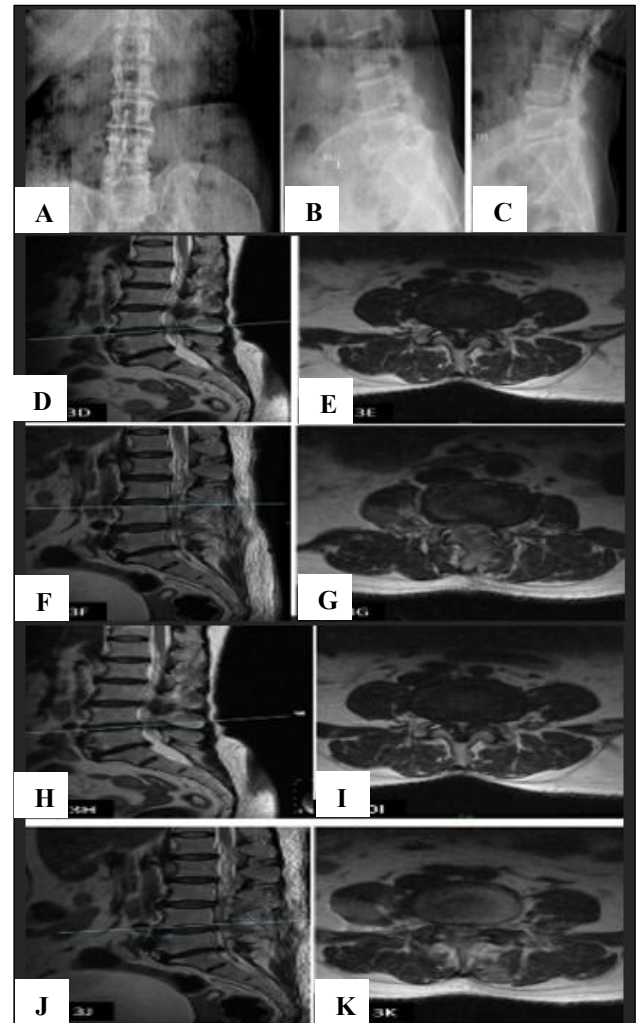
Case Example 3: 65-year-old male with lumbar canal stenosis at both L3-L4 and L4-L5, presenting with left lower limb radiculopathy. (A to C) Show AP, lateral in flexion, and lateral in extension radiographs, D and E) Depict preoperative sagittal and axial T2-weighted MRI images at the L3-L4 level, demonstrating severe neural compression, (F and G) Display preoperative sagittal and axial T2-weighted MRI images at the L4-L5 level, also showing significant neural compression, (H and I) Present postoperative sagittal and axial MRI images at the L3-L4 level, indicating adequate decompression, (J and K) show postoperative sagittal and axial MRI images at the L4-L5 level, confirming satisfactory decompression.
